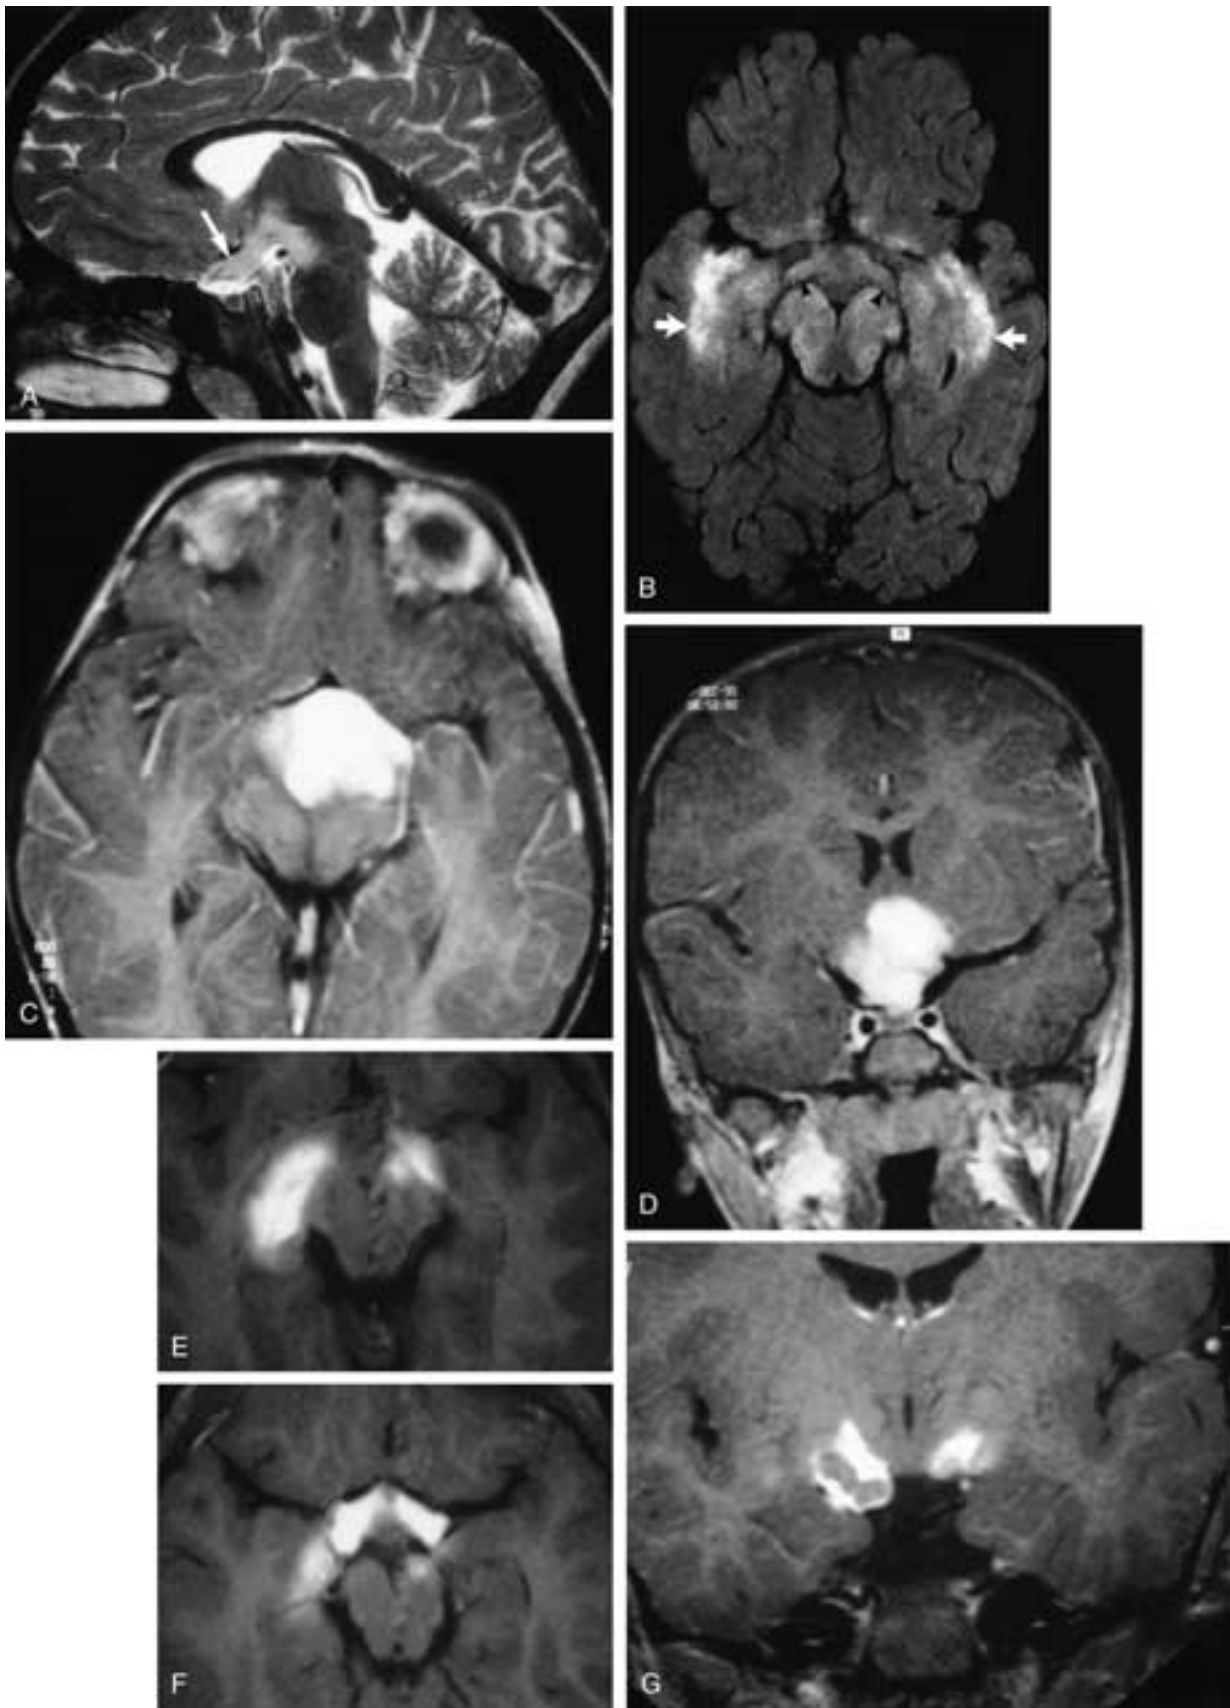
Visual pathway gliomas. A, Sagittal T2-weighted image in a 6-year-old male shows high signal intensity of an enlarged optic chiasm (*arrow*). Tumor extends posteriorly up against the brainstem and superiorly into the hypothalamus. B, FLAIR image in a 3-year-old female with neurofibromatosis type 1, shows involvement of the optic chiasm and optic tracts (*arrowheads*), as well as the brainstem and both medial temporal lobes (Meyer's loops) (*arrows*). C and D, Chiasmatic hypothalamic astrocytoma; C, T1-weighted axial image after contrast injection shows diffuse enhancement of the mass, as does the coronal image in D. E to G, Optic tract extension of chiasmatic glioma in a 6-year-old male with neurofibromatosis type 1. E and F, Axial T1-weighted, fat-suppressed images show contrast-enhanced tumor extending posteriorly from the chiasm into both optic tracts. Coronal T1-weighted, fat-suppressed image shows the right optic tract to be more involved than the left.
